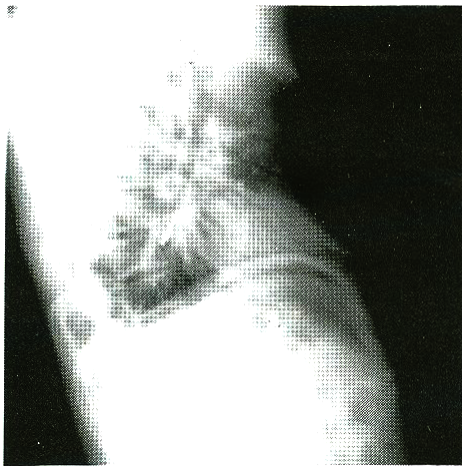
Radiograph of the chest lateral film demonstrating the foreign body
